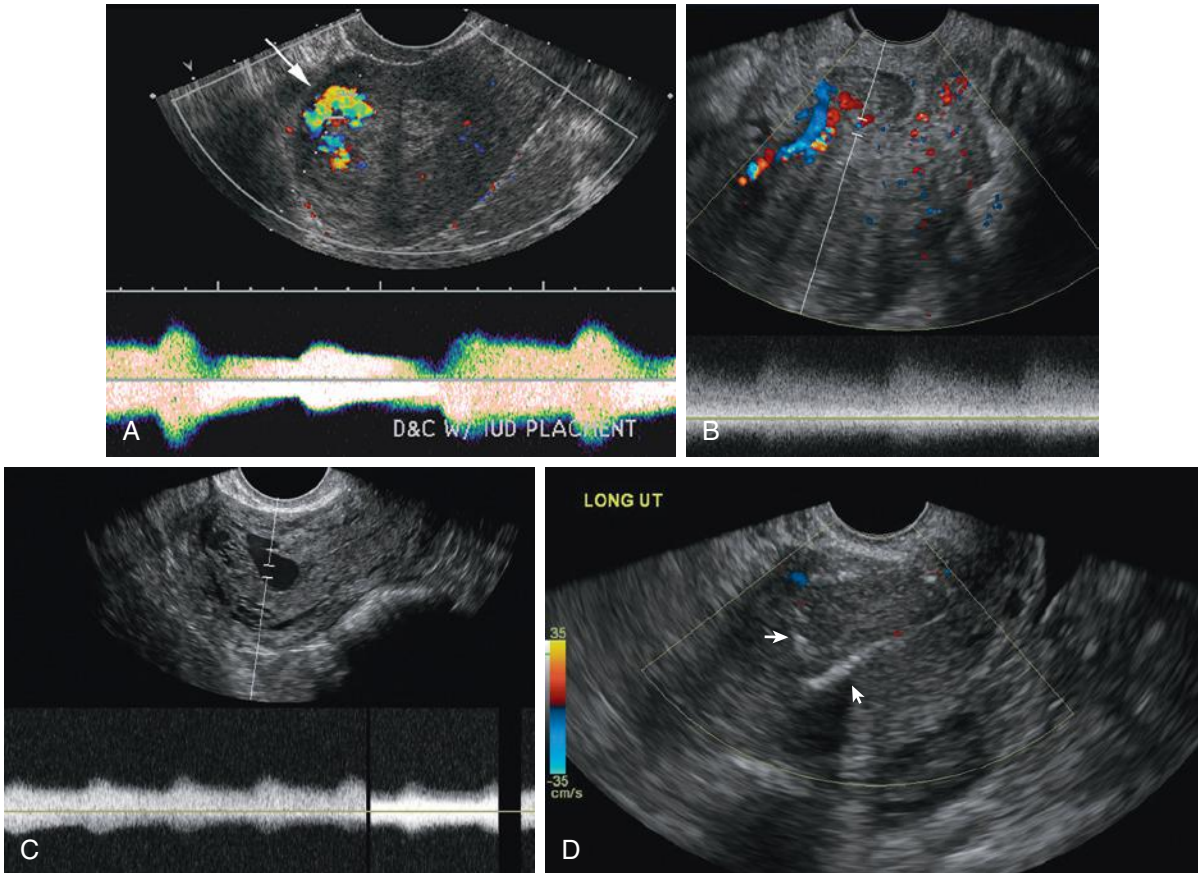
A, Intrauterine arteriovenous malformations (AVMs). This patient presented after dilatation and curettage (D&C) and intrauterine device placement with prolonged heavy bleeding for 1 week. Transvaginal image with color and spectral Doppler demonstrates a large fundal iatrogenic AVM (*arrow*) with characteristic low-resistance arterial flow pattern with increased systolic and diastolic flow. Gestational trophoblastic disease was excluded by negative human chorionic gonadotropin levels. B, Exactly similar Doppler appearance in a different patient with retained products of conception (RPOC). C, Transvaginal sonogram of 23-year-old woman who presented with an AVM from previous D&C with persistent vaginal bleeding following uterine artery embolization $\times 2$. Persistent dominant vascular nidus was noted in the anterior myometrium demonstrating a high-velocity low-resistance spectral Doppler waveform. D, After direct treatment of the nidus as well as repeat uterine artery embolization the AVM is no longer present and the vaginal bleeding resolved. Note echogenic embolization material in the anterior wall of the uterus and endometrial canal (*arrows*).
